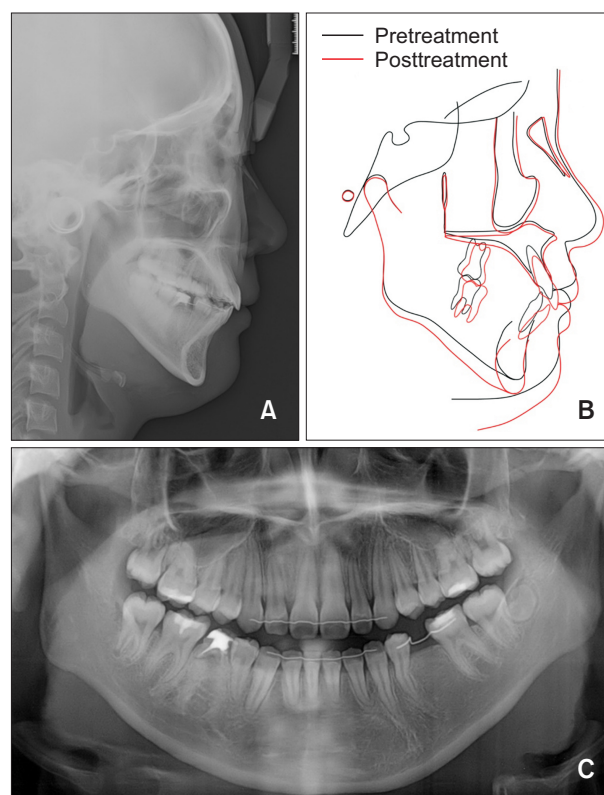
A, Posttreatment lateral cephalogram. B, Superimpositions before and after orthodontic treatment. C, Posttreatment panoramic radiograph.
